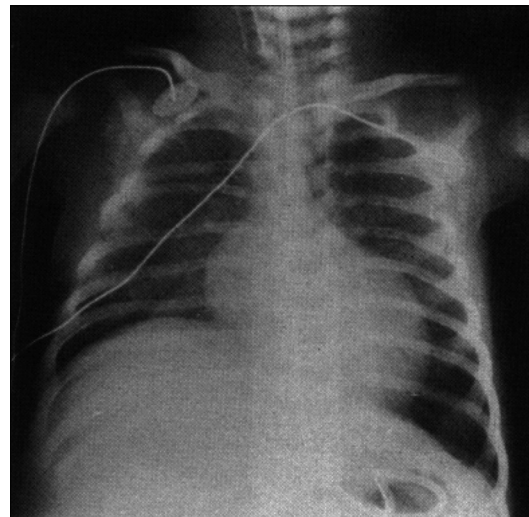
Chest X-ray showing raised hemidiaphragm on the right side suggestive of right-sided phrenic nerve injury. (Reproduced with permission from [29].)
